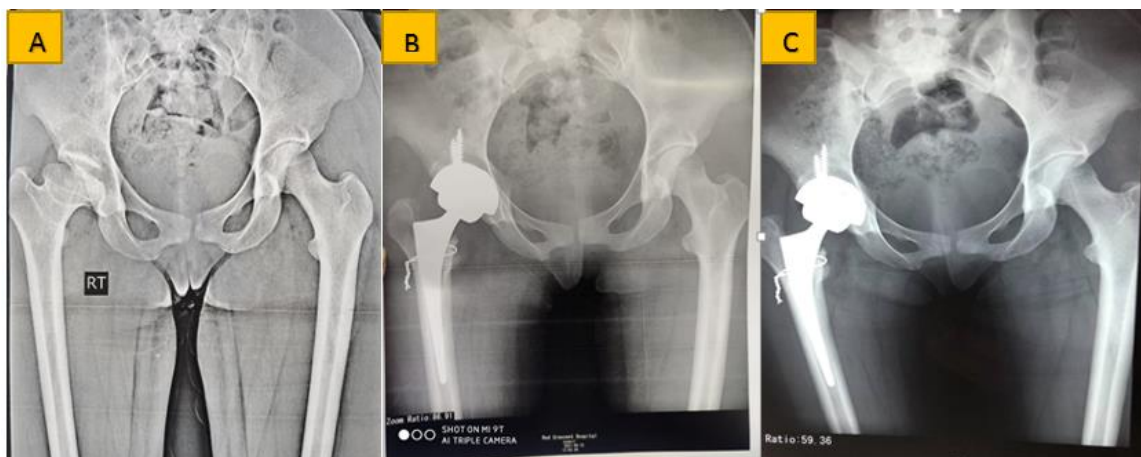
A Plain X ray pelvis AP showing Rt hip osteoarthritis (preoperative) (b) postoperative x-ray AP view showing RT hip arthroplasty with intraoperative calcar cracks managed with cerclage wiring (c)12 months postoperative x-ray last HHS was 93.
